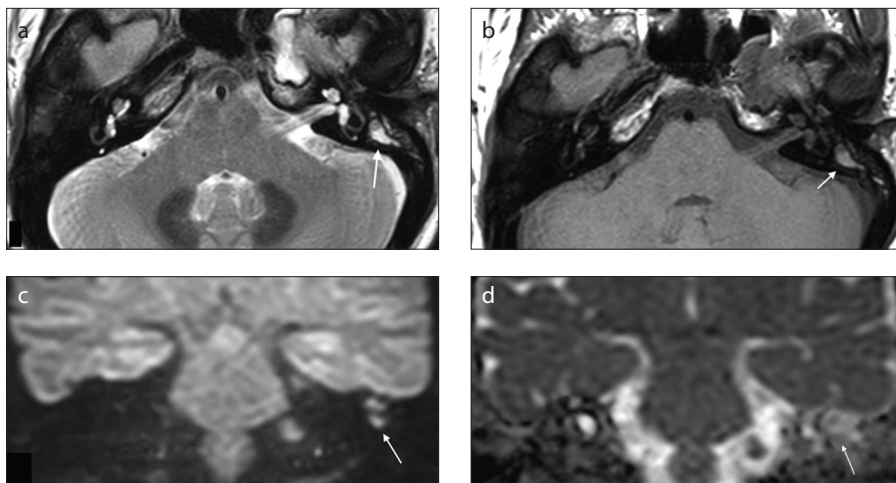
a–d. A 45-year-old woman with chronic middle ear inflammation and granulation tissue. Axial T2-weighted image (a) shows a high T2 signal lesion (arrow), with mild signal increase compared with the brain parenchyma on axial T1-weighted image (b). The lesion demonstrates high signal on DWI (c) but is isointense compared with the temporal cortex and has mixed signal on the ADC map (d).
